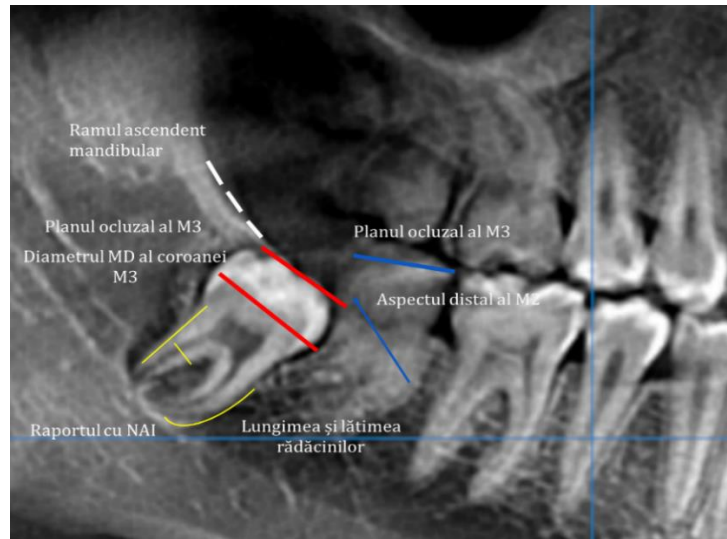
Panoramic radiography section with assessment of parameters
